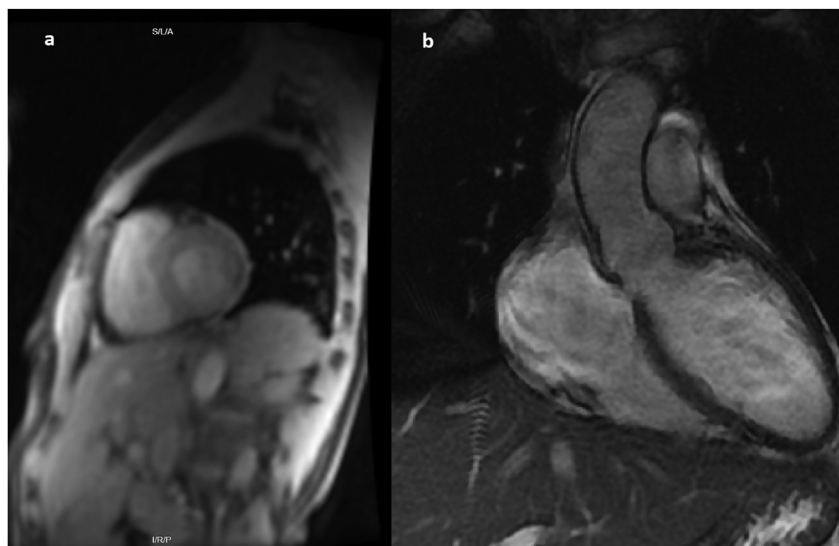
a and b. Cardiac MRI images demonstrating extensive delayed gadolinium enhancement.
